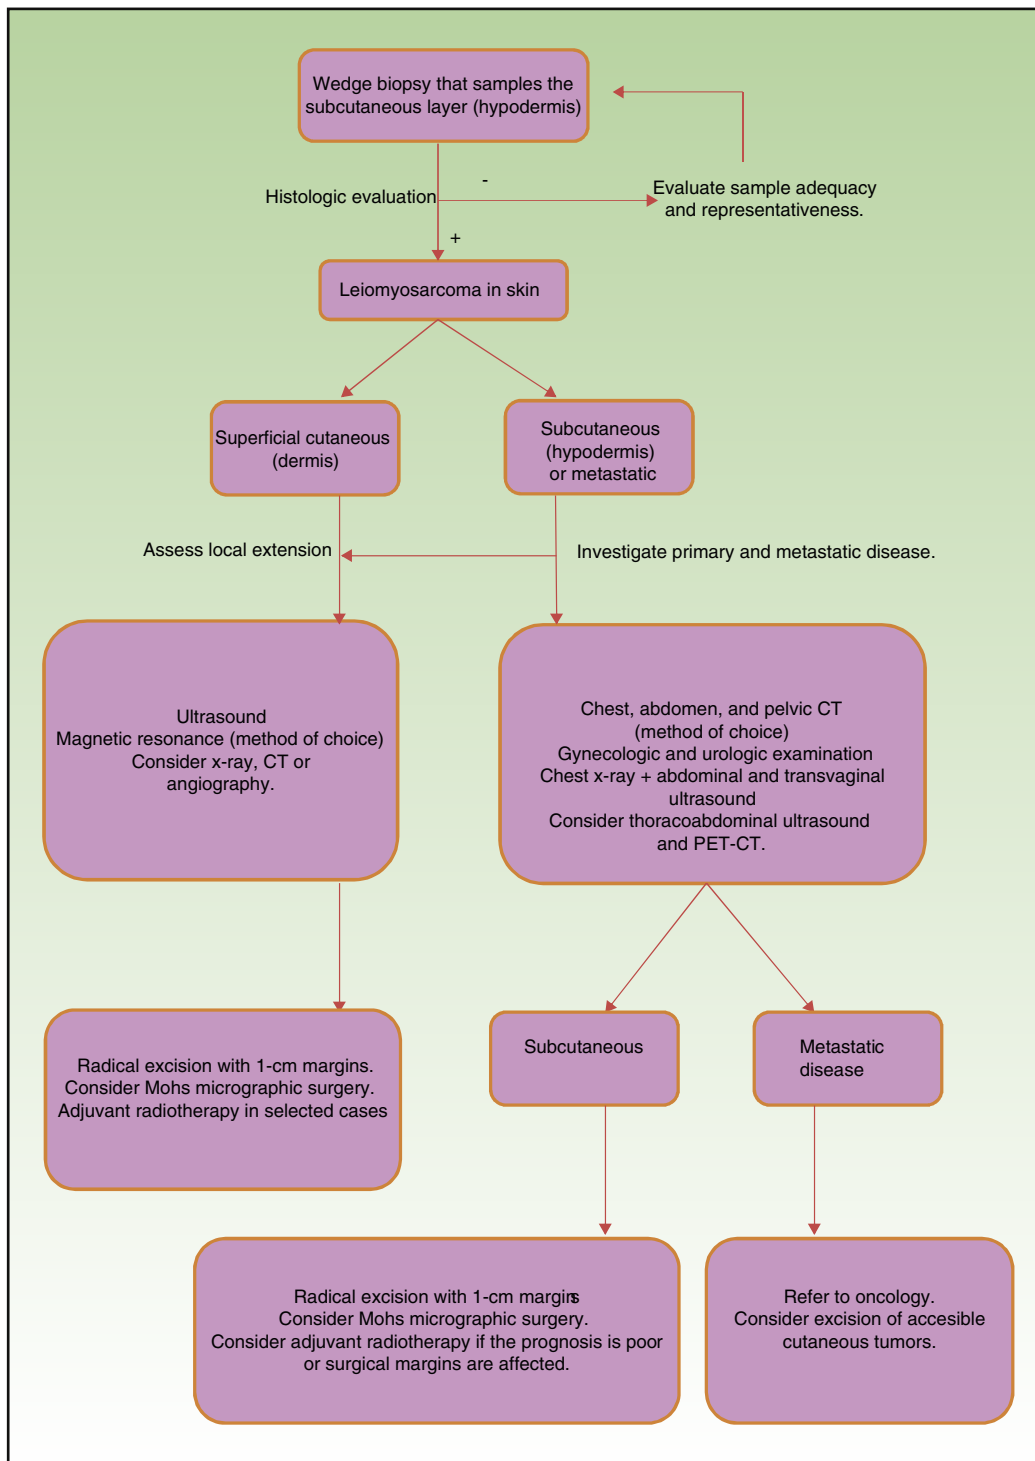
Algorithm to guide the diagnosis and management of leiomyosarcomas of the skin. CT refers to computed tomography; PET-CT, positron emission CT.
